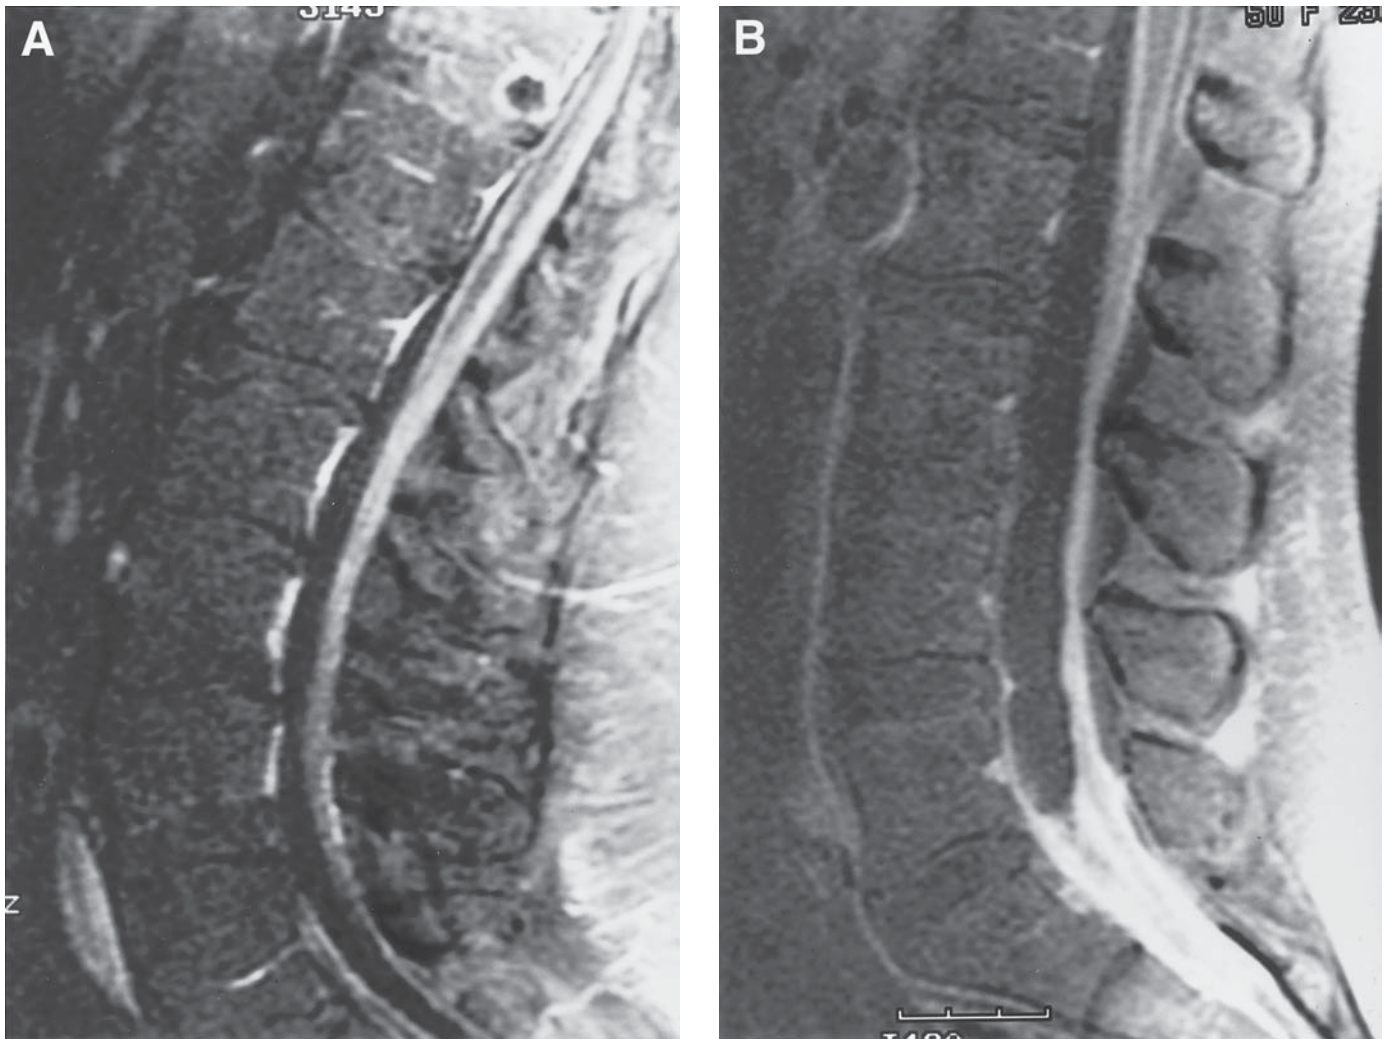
Look-alike spine lesions. (A) This 45-yr-old patient presented with headache and back pain. Opening pressure on lumbar puncture was 50 cm of water. MRI obtained after gadolinium administration with fat saturation demonstrates a round hypointense focus in the T-9 vertebra and thick pial and nerve root enhancement. Vertebral body biopsy confirmed a sclerotic adenocarcinoma metastasis of unknown primary. (B) This 50-yr-old patient had low back pain treated with multiple epidural steroid injections 6 mo earlier. She presented to the emergency room with severe low back pain and fever. Sagittal, enhanced MRI shows thick enhancement of the nerve roots of the cauda equina, mimicking carcinomatosis. CSF cultures grew *Neisseria sicca*.
